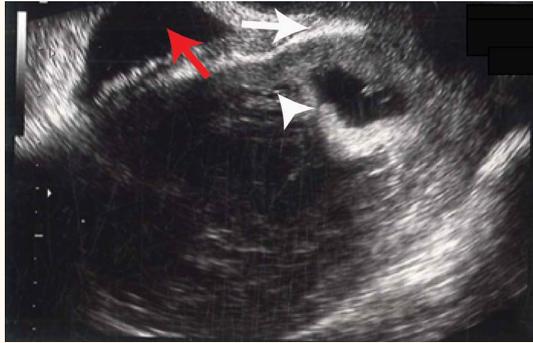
Vaginal ultrasound showing a pregnancy in the Caesarean scar site (white arrow) growing towards the endometrial cavity (arrowhead). The bladder can also be observed (red arrow).
